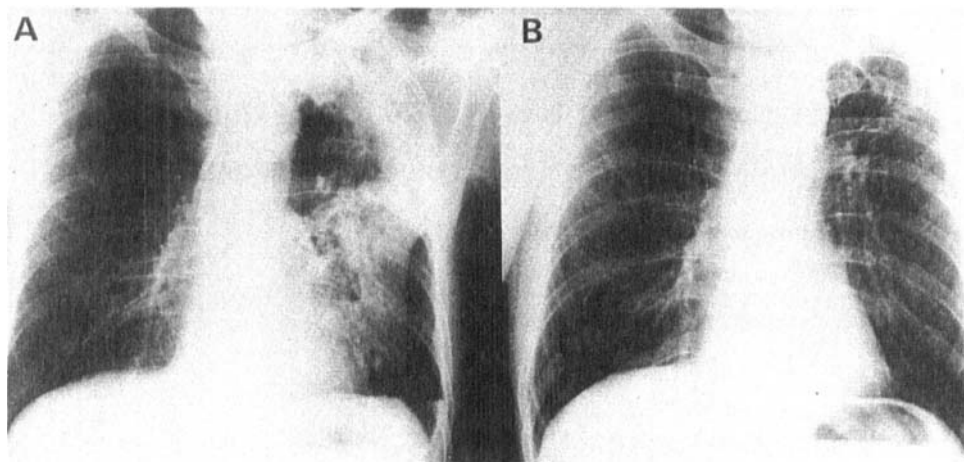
A. Chest roentgenogram obtained after 14 days of antimicrobial therapy showing left upper lobe cavitory disease, loculated hydropneumothorax, and diffuse infiltrates throughout the left lung. B. Resolution of necrotizing *Aspergillus* infection after therapy with 2 grams of amphotericin B.
